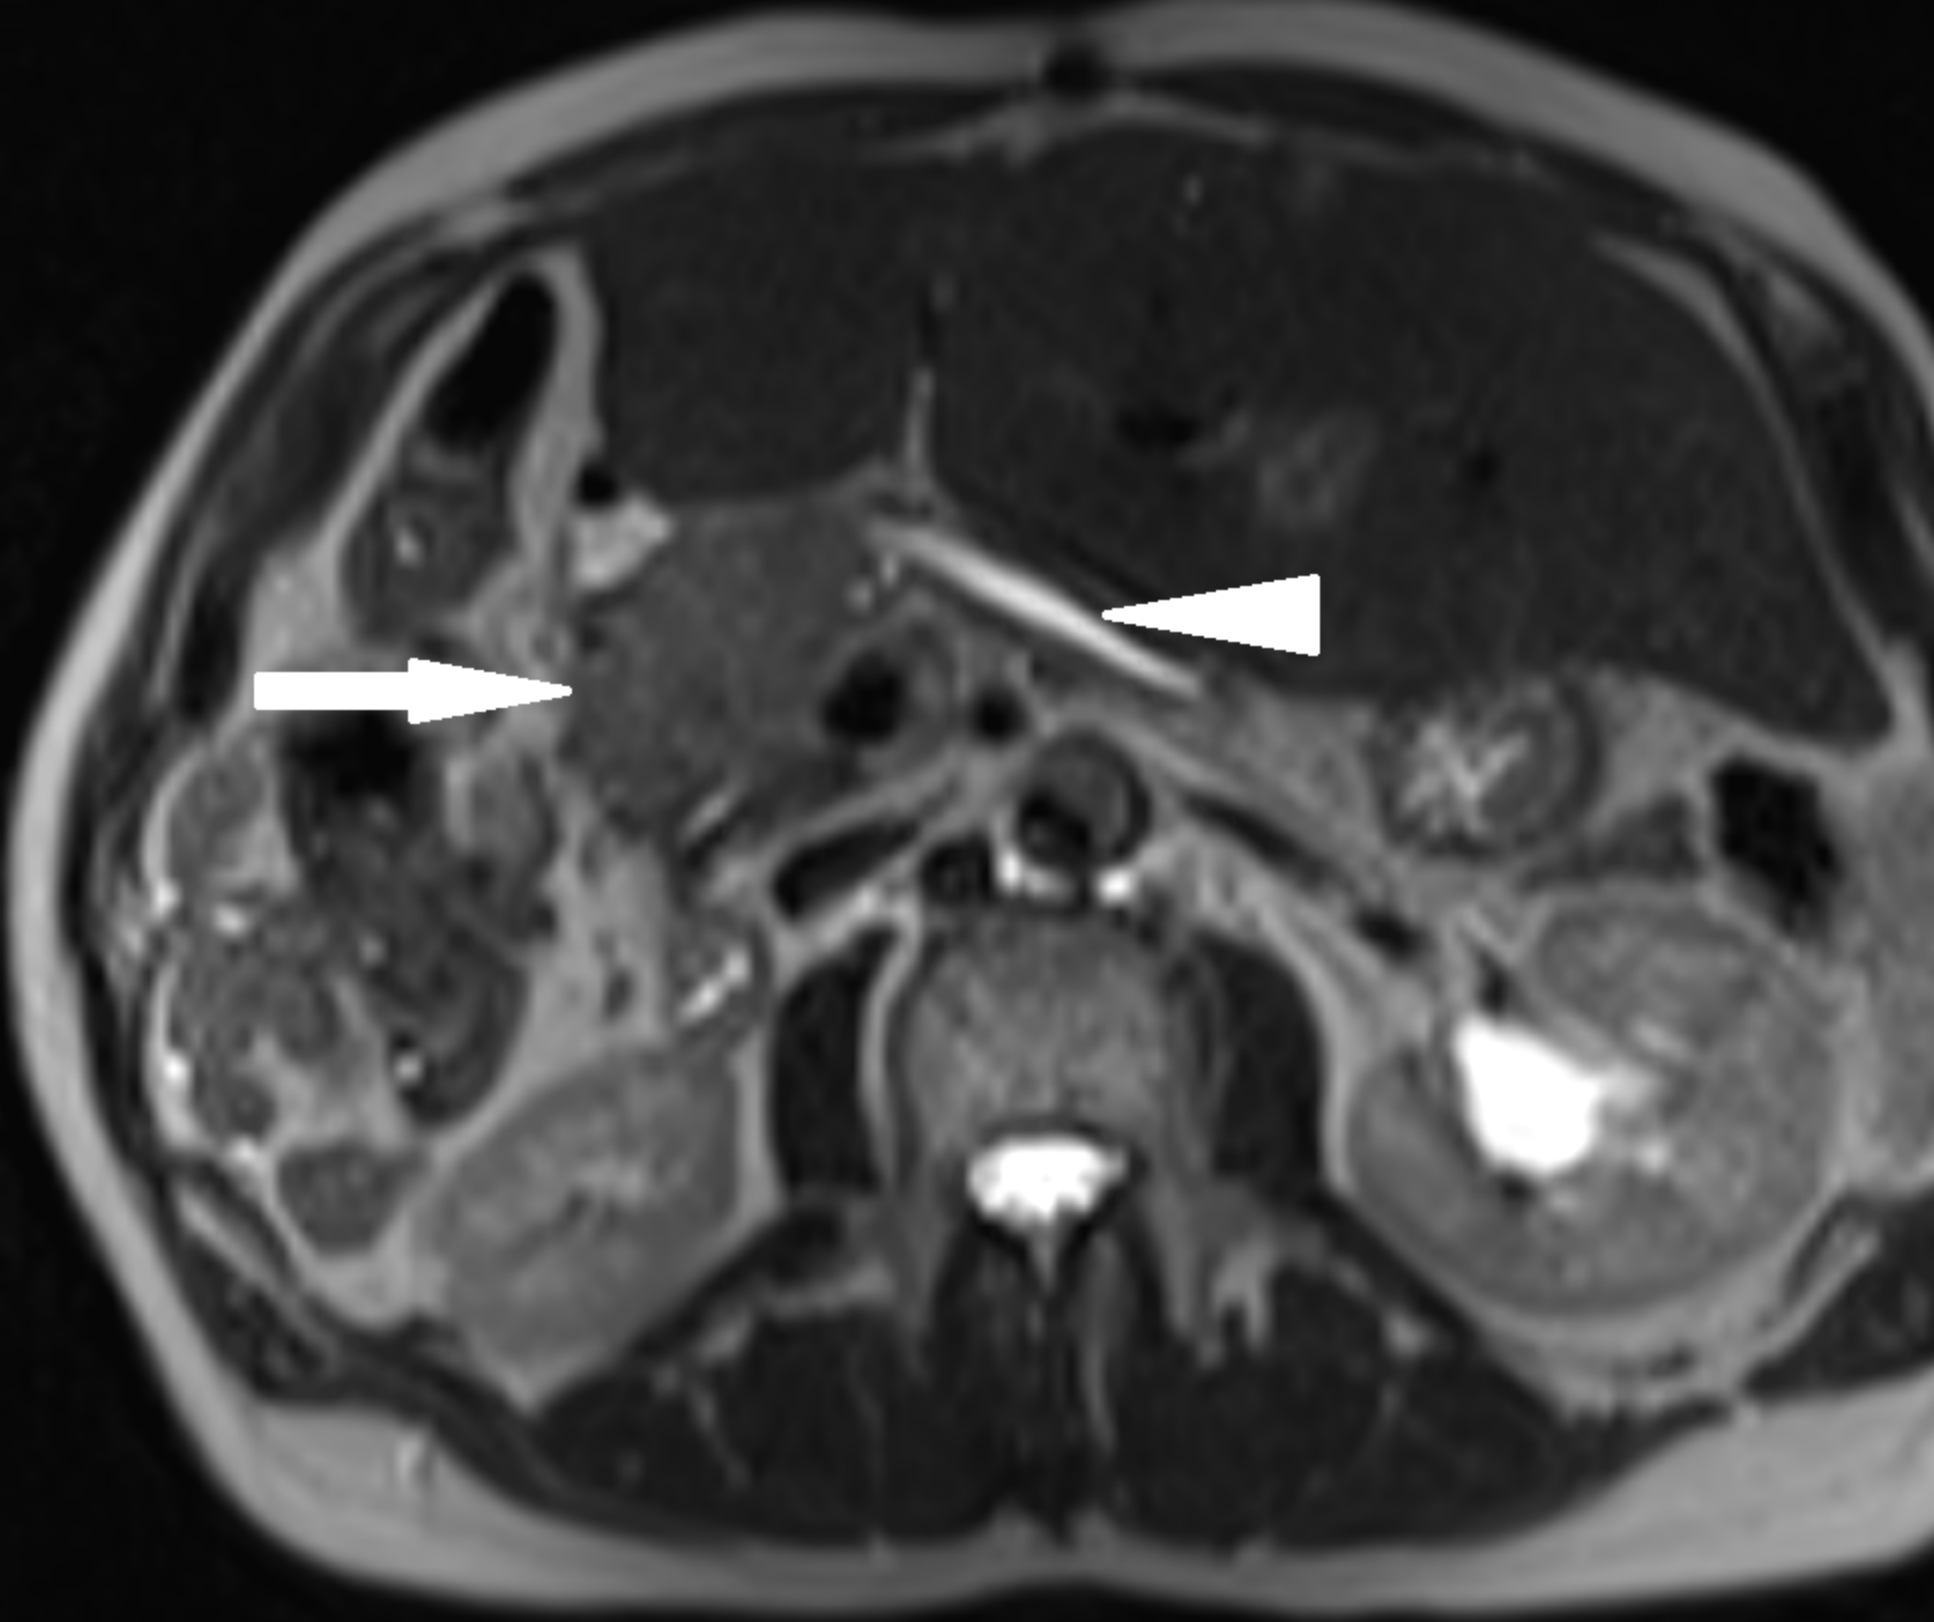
Magnetic resonance imaging (MRI) examination in a 61-year-old man with acinar cell carcinoma (ACC) of the pancreatic head. A, Fat-saturated T1-weighted MR image of the abdomen in the transverse plane shows tumor (arrow) of the pancreatic head. B, T2-weighted MR image of the abdomen in the transverse plane shows that the tumor (arrow) is hyperintense relative to the pancreatic parenchyma. The tumor is responsible for enlargement of the Wirsung duct (arrowhead). C, Diffusion-weighted MR images of the abdomen in the transverse plane obtained with b value of 1000 s/mm² show hyperintense tumor (arrow) indicating restricted diffusion. The tumor has an apparent diffusion coefficient of 1.061×10^{-3} mm²/s. D, T1-weighted MR image of the abdomen in the transverse plane obtained during the arterial phase after intravenous administration of a gadolinium chelate shows hypervascular hepatic metastasis (arrow).
